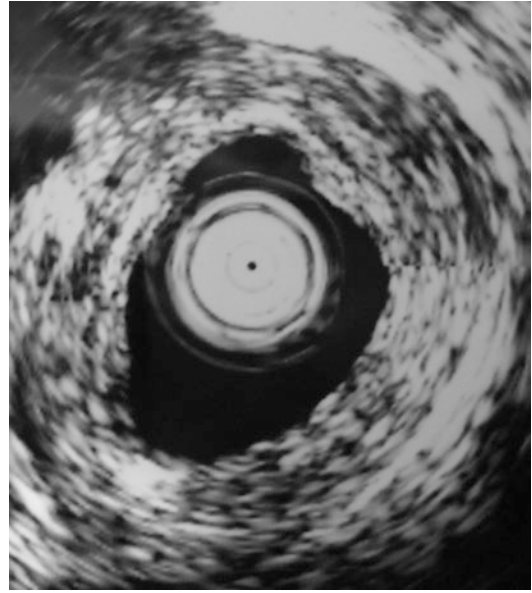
The typical appearance of a fibrotic anastomosis on endoscopic ultrasound
